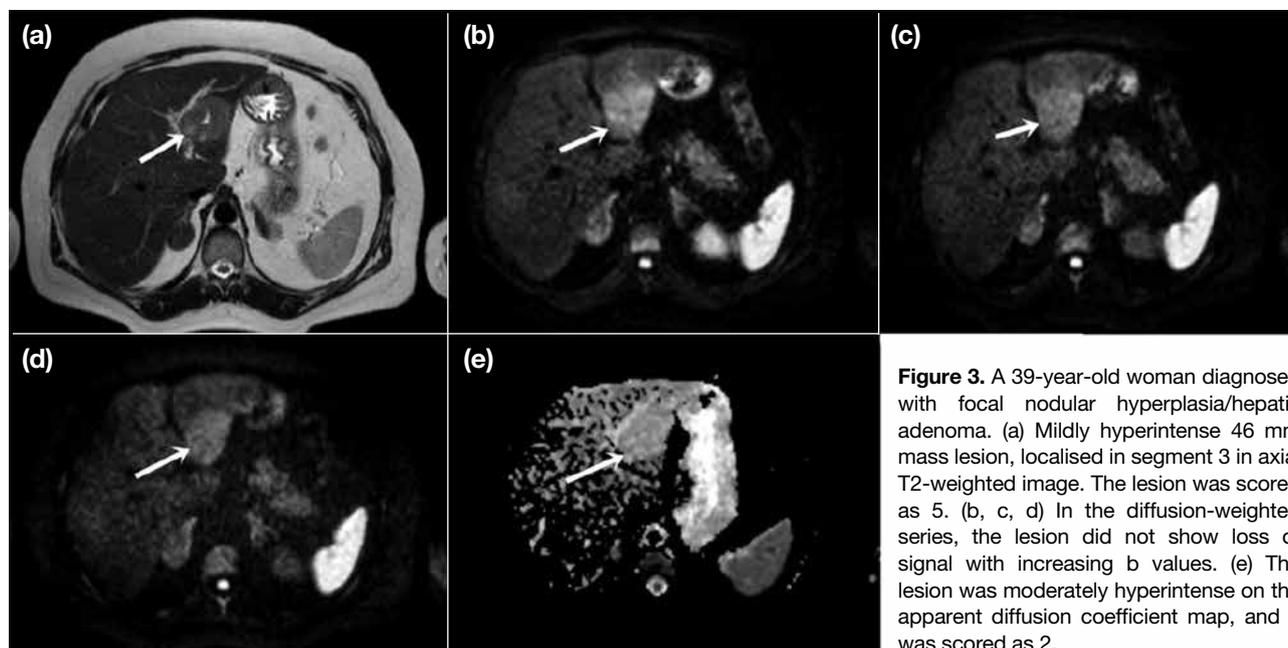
A 39-year-old woman diagnosed with focal nodular hyperplasia/hepatic adenoma. (a) Mildly hyperintense 46 mm mass lesion, localised in segment 3 in axial T2-weighted image. The lesion was scored as 5. (b, c, d) In the diffusion-weighted series, the lesion did not show loss of signal with increasing b values. (e) The lesion was moderately hyperintense on the apparent diffusion coefficient map, and it was scored as 2.
